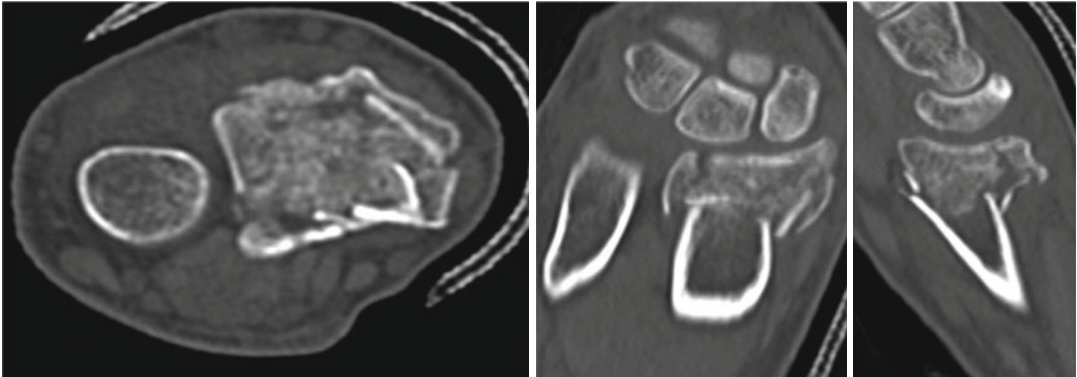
CT scan in axial, coronal and sagittal plane
